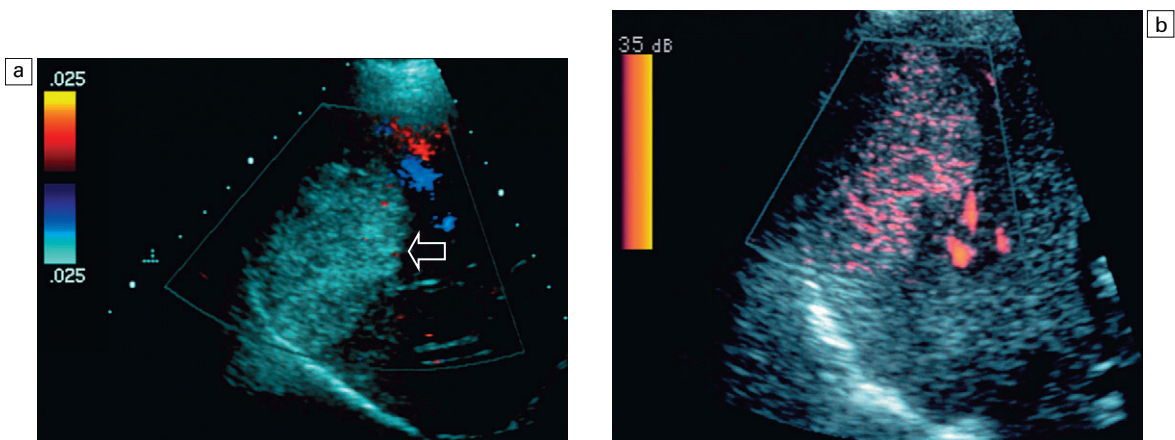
(a) Transverse colour Doppler image of the right lobe of the liver. A large echogenic mass is easily identified (arrow). No flow is perceived with the mass by colour Doppler despite settings at the most sensitive level. (b) Power Doppler image of this lesion shows a leaf like pattern of signal within the mass. This is most likely an artifact based on motion discrimination. With power Doppler artifact tends to occur within the pixels of high intensity reflection. Biopsy did confirm this lesion to be a haemangioma.
